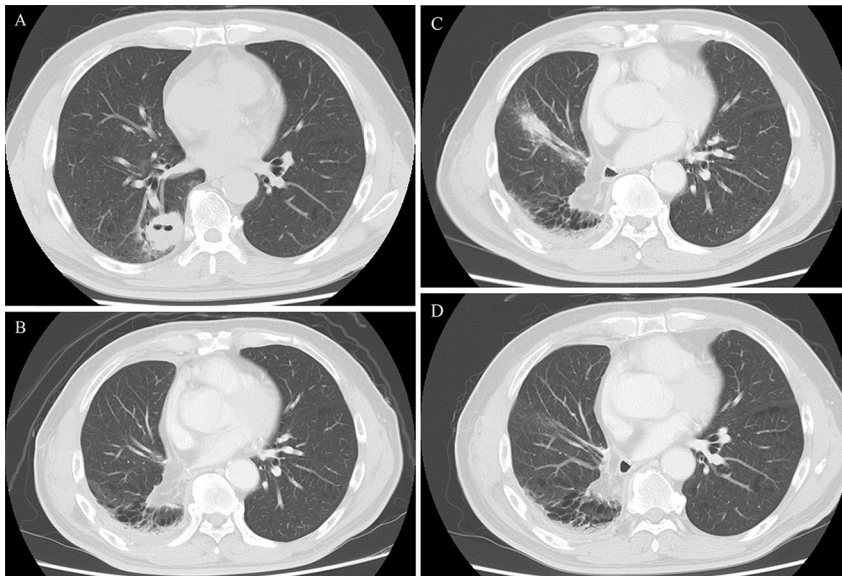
CT of the thorax. (A) A CT scan 20 months before the consultation visit shows a mass lesion (36 × 34 mm) in the right lower lung lobe. (B) A CT scan after the right lower lobectomy, which was performed 16 months before the consultation visit, shows no abnormality. (C) A CT scan taken 3 weeks before the consultation visit shows a nodular lesion (24 × 22 mm) in the right middle lung lobe. (D) A CT scan at 5 months after the completion of treatment with praziquantel reveals no nodular lesion in the right middle lung lobe.
